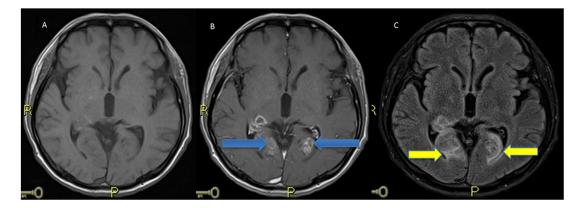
Multisequential Magnetic resonance imaging
